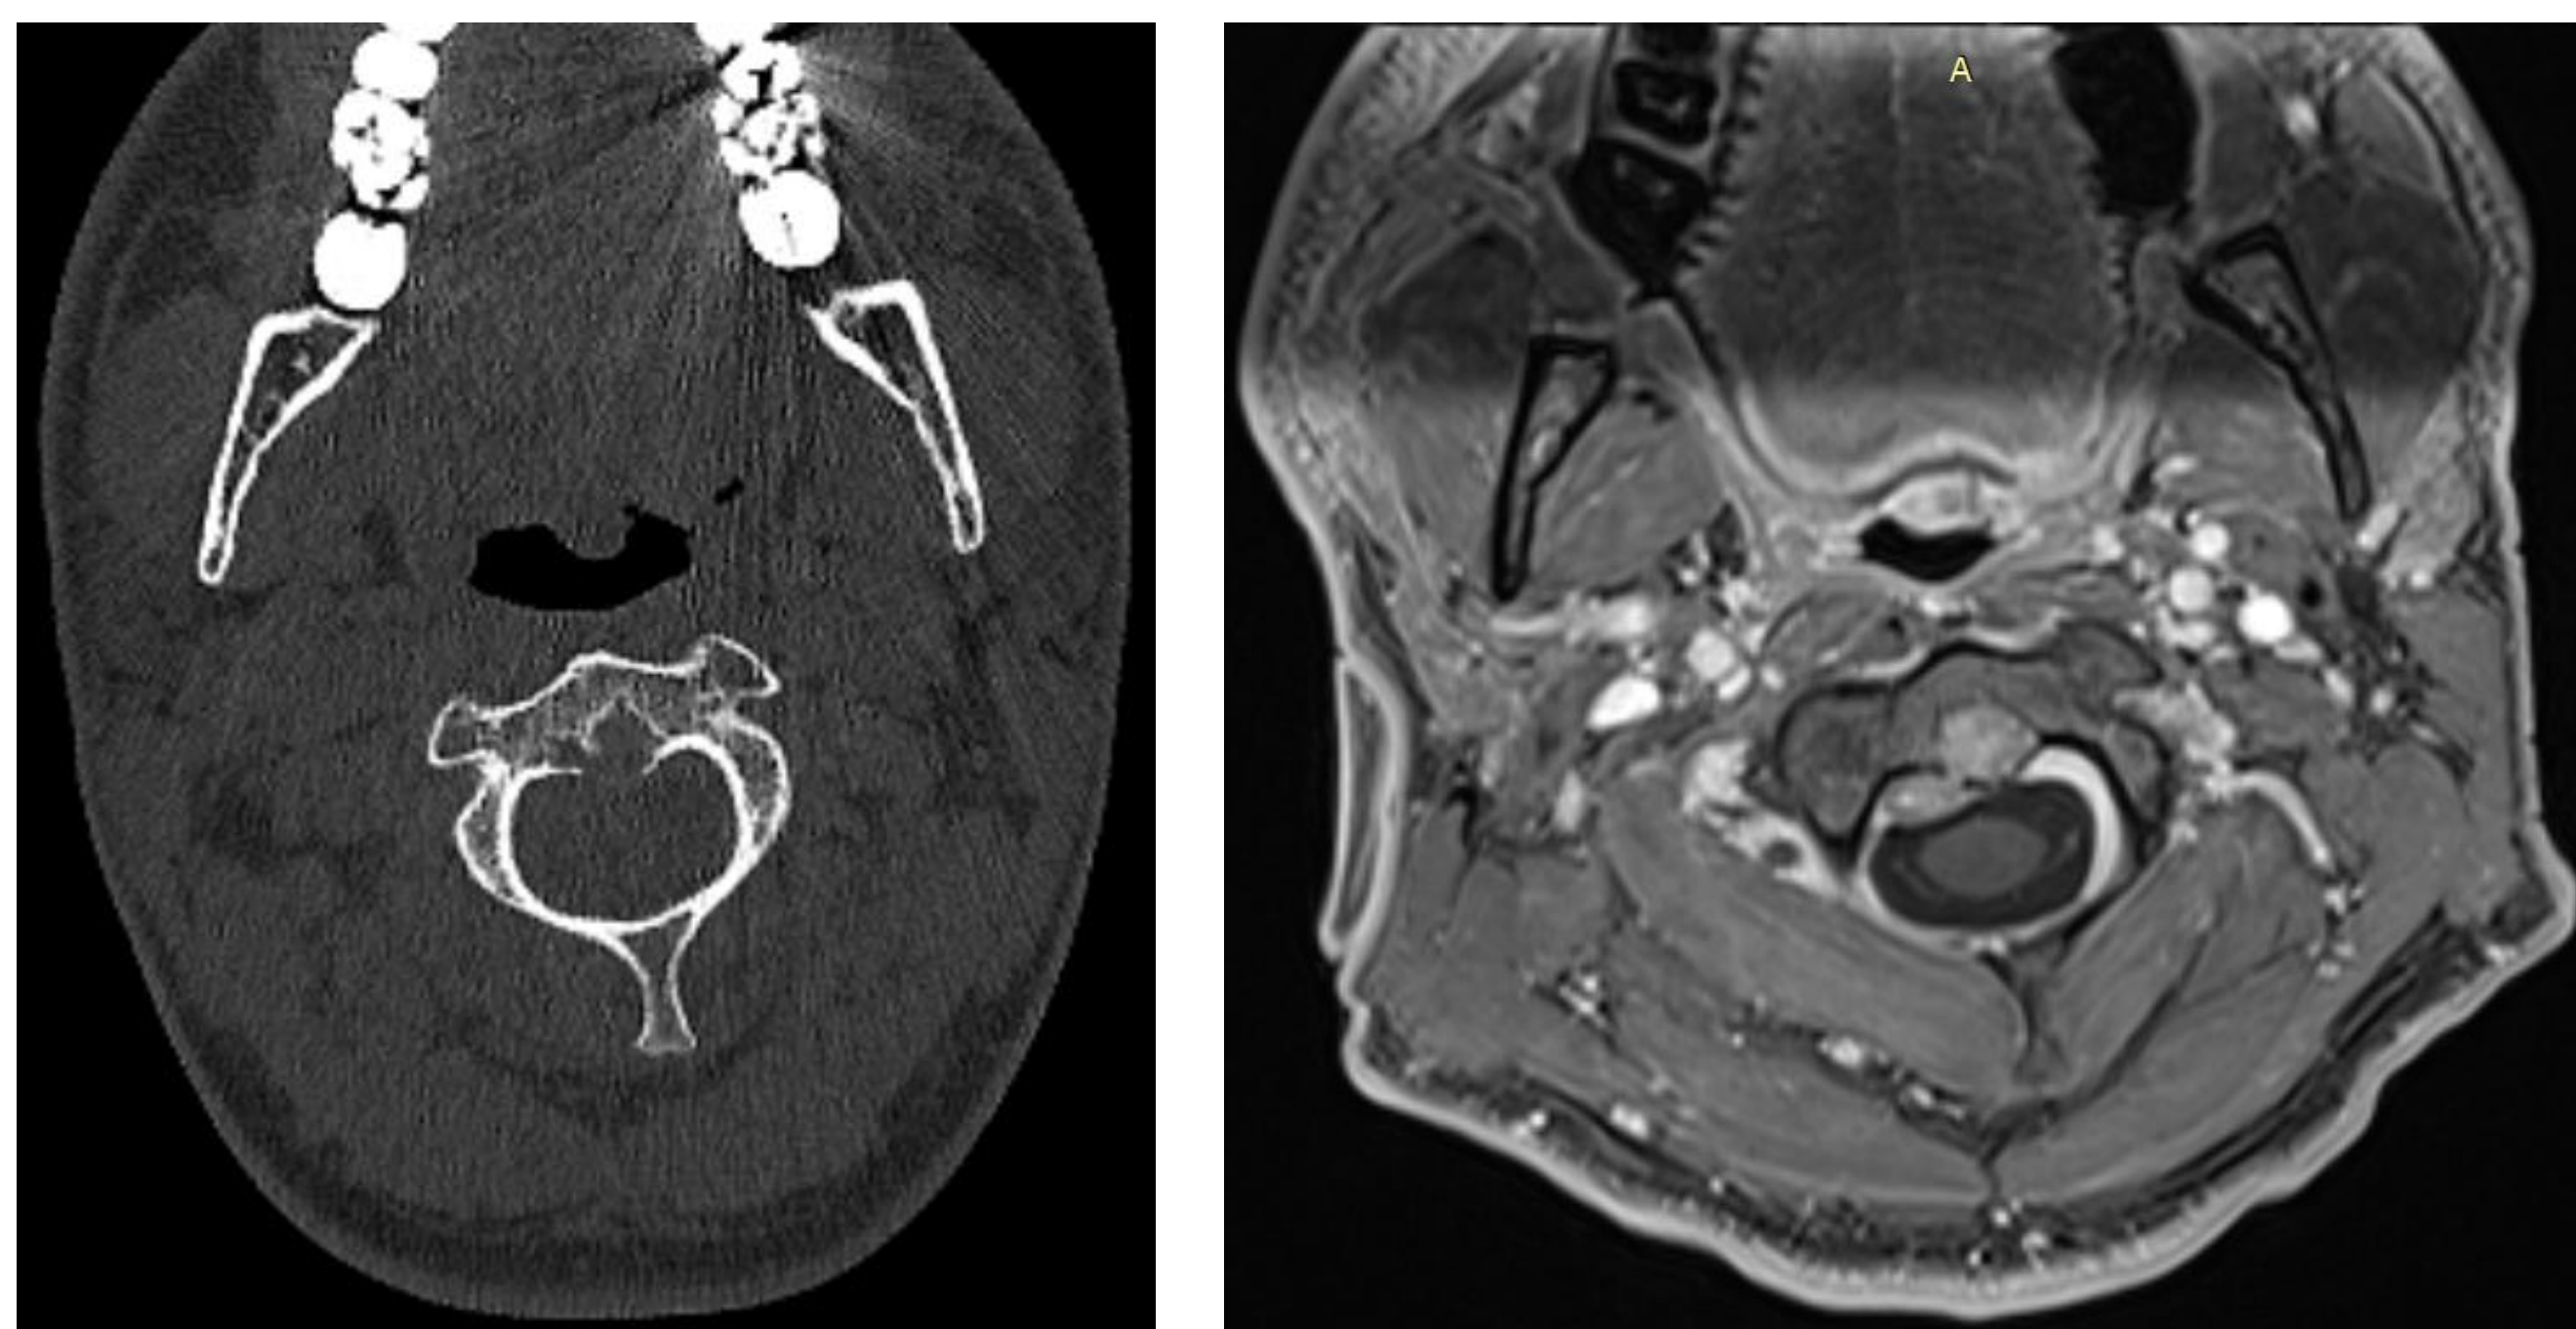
Axial CT and MRI (T1, post-contrast). Lesion can be seen on the posterior aspect of the C2 vertebral body.
